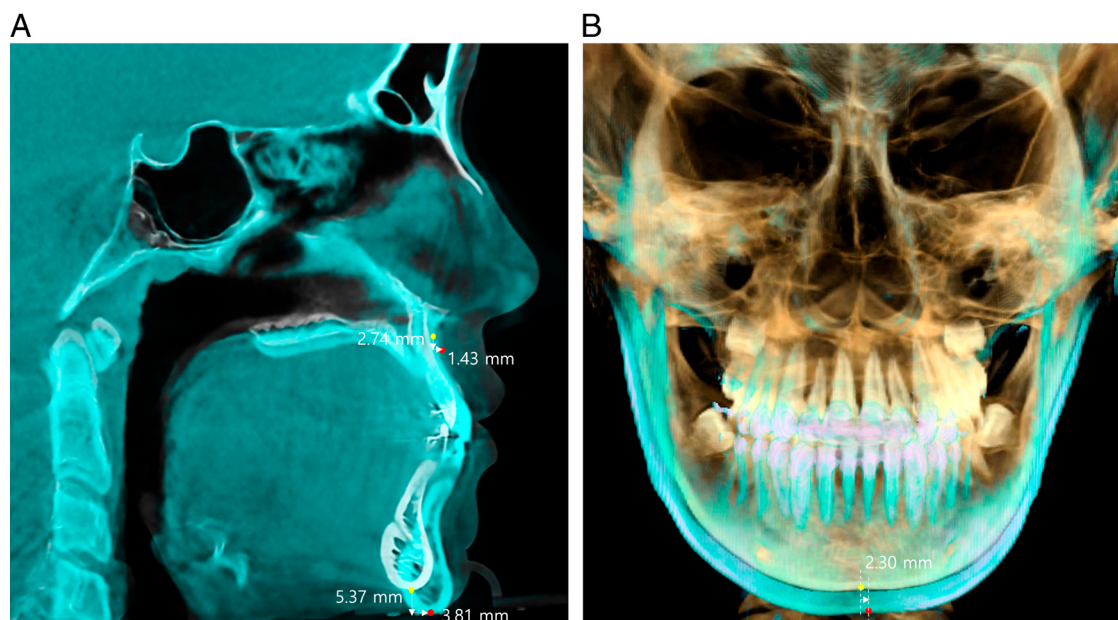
Cone-beam computed tomography superimposition between posttreatment and 3-year follow-up images. Yellow and red dots denote the post-treatment measurements and 3-year follow-up measurements, respectively. (A) Lateral view. More prominent forward growth of the mandible than the maxilla. (B) Frontal view. Menton deviation to the left.
